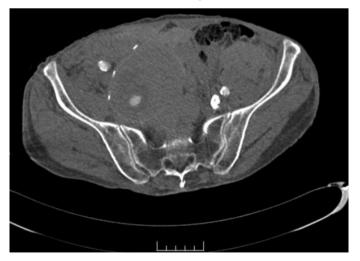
Preoperative CT view of aneurysm CT: Computed tomography
